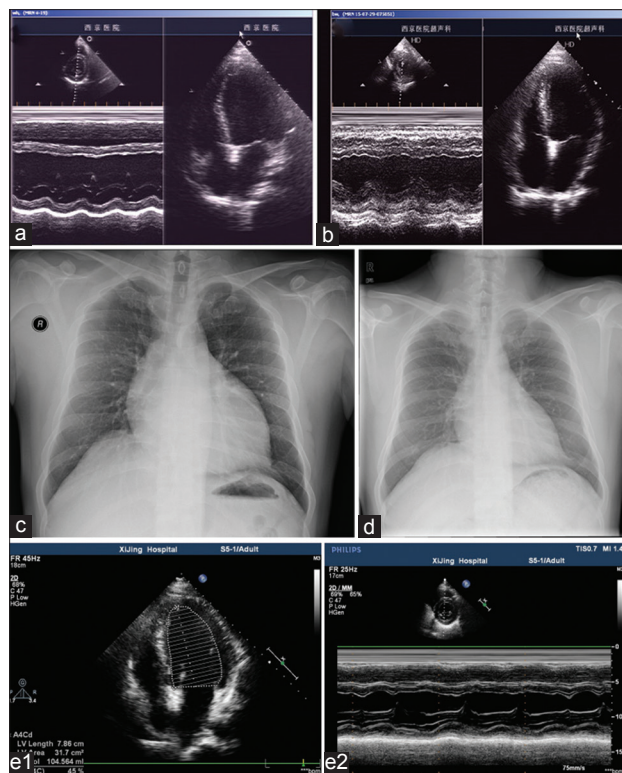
Echocardiogram (a) at admission, (b) after receiving supramaximal doses valsartan for 3 months, (e1 and e2) after receiving supramaximal doses valsartan for 8 months; chest X-ray (c) at admission, (d) after receiving supramaximal doses valsartan for 3 months.
